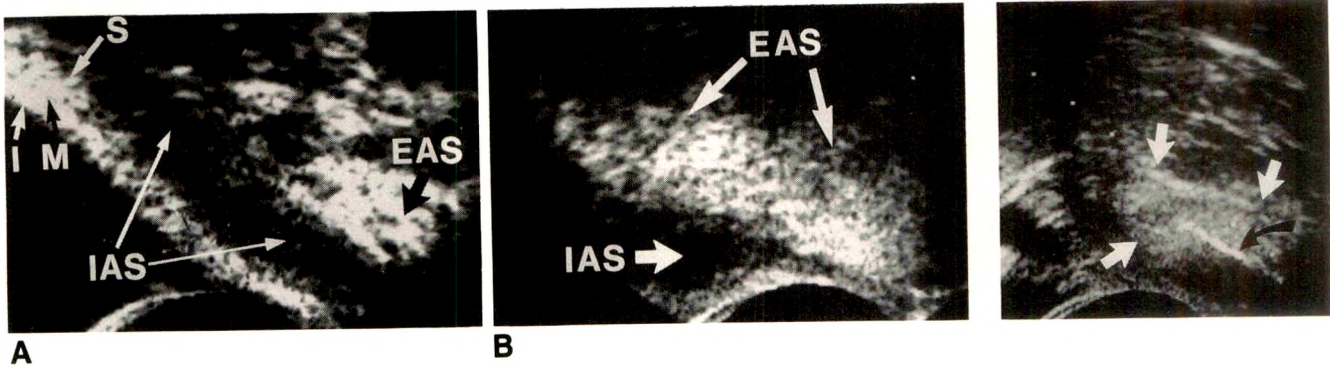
Endoluminal anal sonograms. Longitudinal images (left is toward patient's head).
